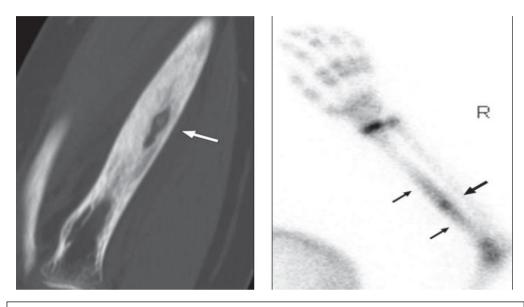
Coronal CT image – oval shaped nidus (*arrow*) with central calcification in radial diaphysis with surrounding sclerosis. Technetium-99 bone scintigraphy shows double-density sign (3).
